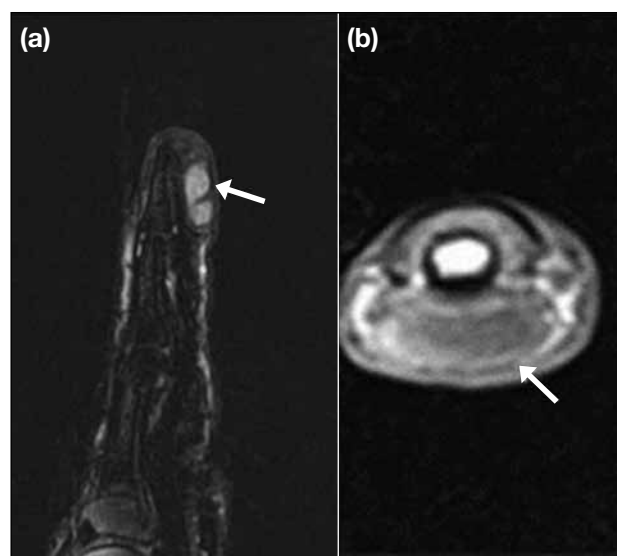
Epidermoid inclusion cyst in a 53-year-old man who presented with left index finger mass: (a) Sagittal T2-weighted magnetic resonance image showing a lobulated circumscribed mass (arrow) over the volar aspect of the index finger, at the distal phalangeal level with homogeneous hyperintense signal and thin hypointense internal septum. (b) Post-contrast T1-weighted axial magnetic resonance image showing mild peripheral incomplete rim enhancement while its internal content remains non-enhancing.
